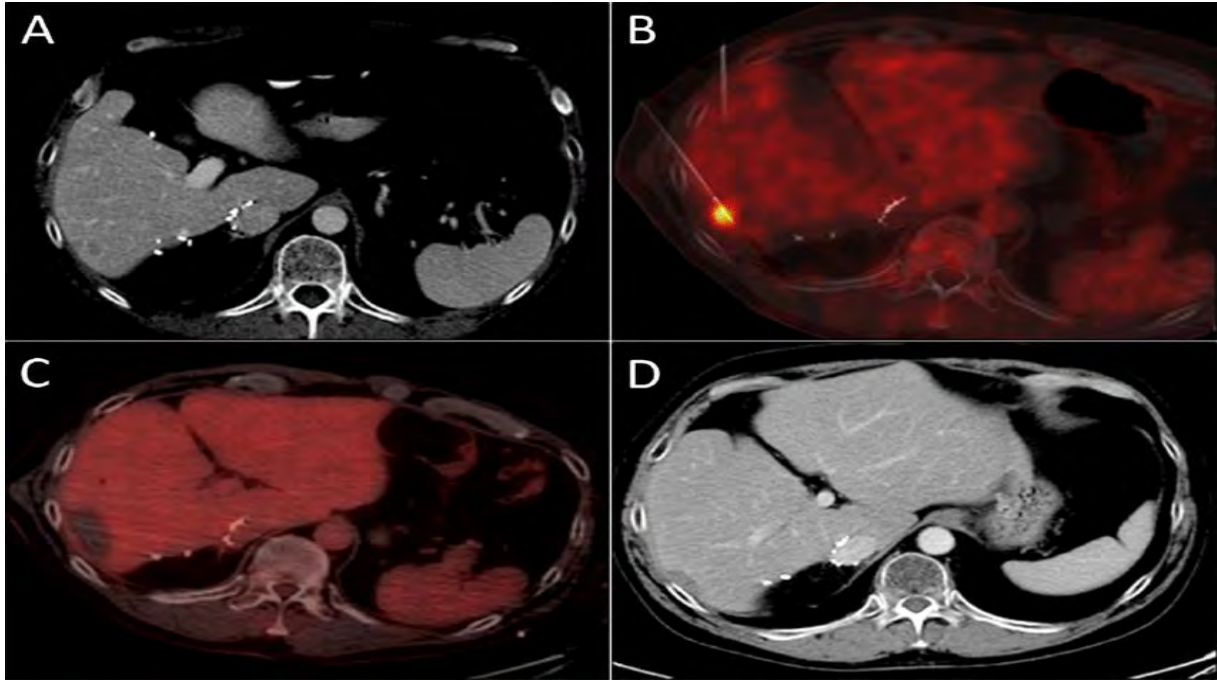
CT-guided radiofrequency ablation for liver treatment
